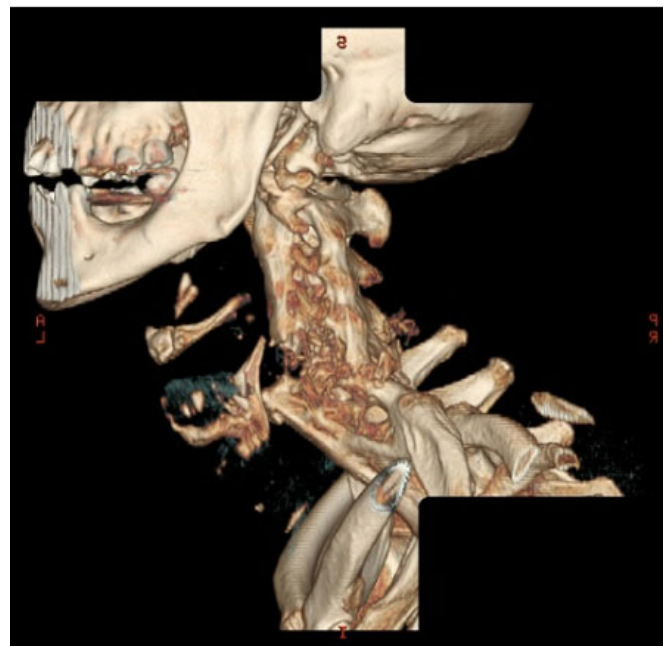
3D reconstruction of pre-operative computed tomography.
